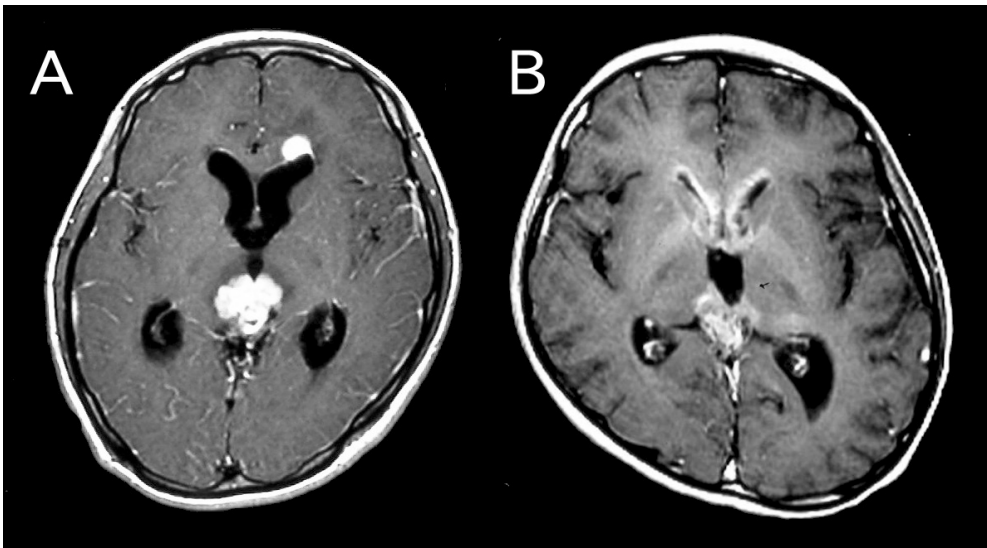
MRI scans obtained at initial presentation, showing dissemination along the cerebrospinal fluid or subpial space in an 18-year-old boy (A) and a 13-year-old boy (B).
